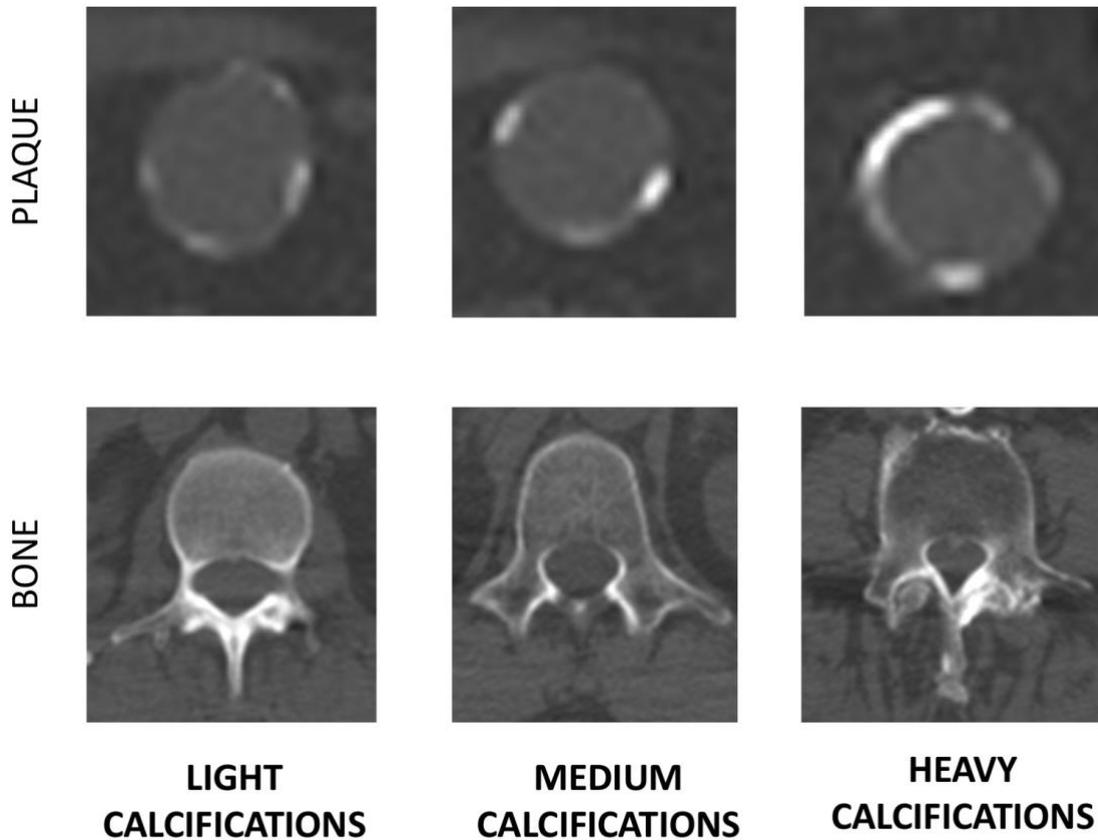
Density trabecular bone and in the aortic plaque. In the three top panels are displayed low-dose CT images depicting examples of typical “light”, “medium” and “heavy” plaques. Directly below (middle panels) are displayed CT slices of the trabecular bone from the same patients.
